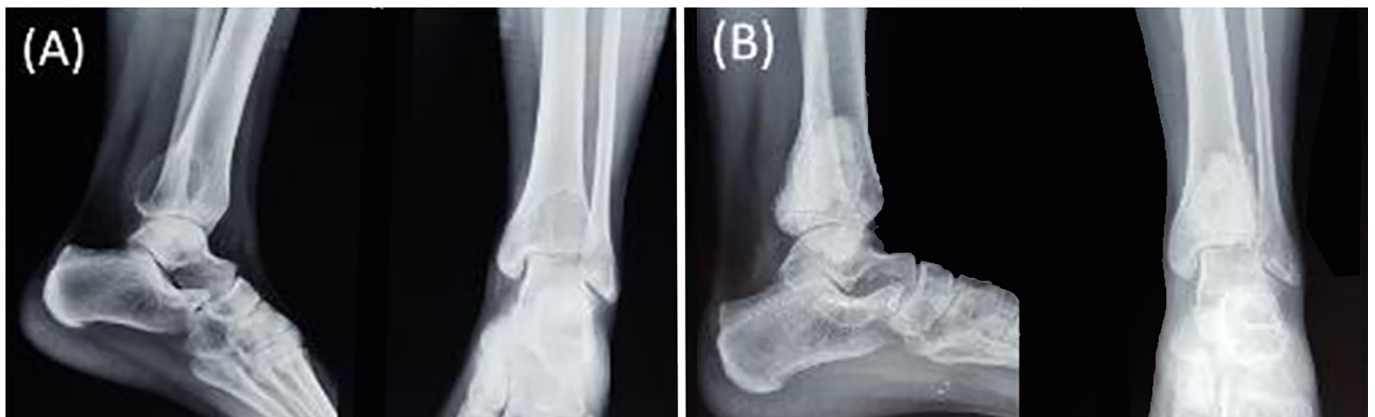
(A) Anteroposterior and lateral radiograph of a 21-year-old female with giant cell tumor of the distal tibia B) Two years after undergoing extended curettage and subchondral bone graft and cementing.
